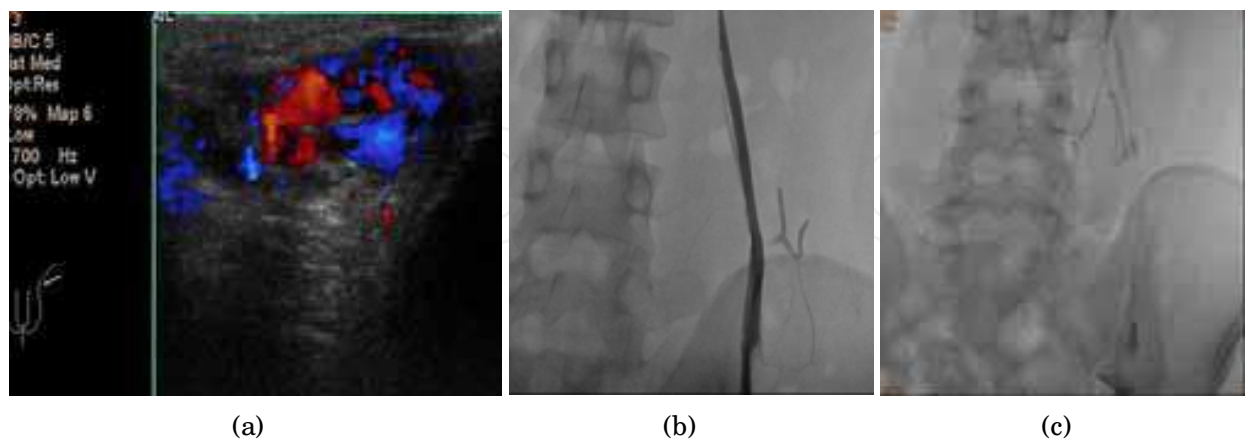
Recurrent varicoceles. A 21-year-old male presented with a recurrent scrotal mass after a high ligation of internal spermatic vein (ISV) 2 years previously. (a) Sonographic diagnosis of reflux flow in the dilated left pampiniform plexus; (b) trans-jugular venography demonstrated patency of the left ISV; (c) embolization with coils successfully treated the recurrence
